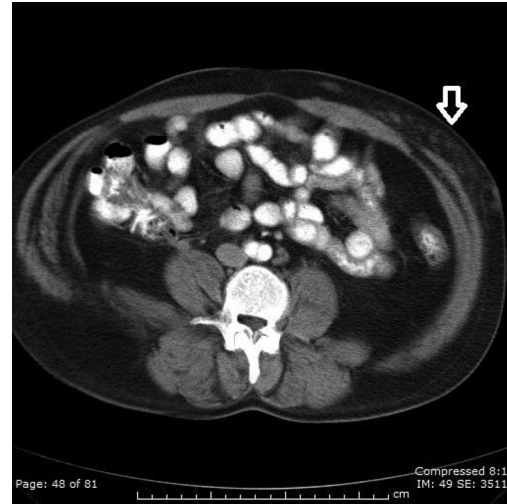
Proteus Syndrome in a 26-year-old male. Axial CT. Note soft-tissue infiltration of the left anterior abdominal wall fat (white open arrow).
